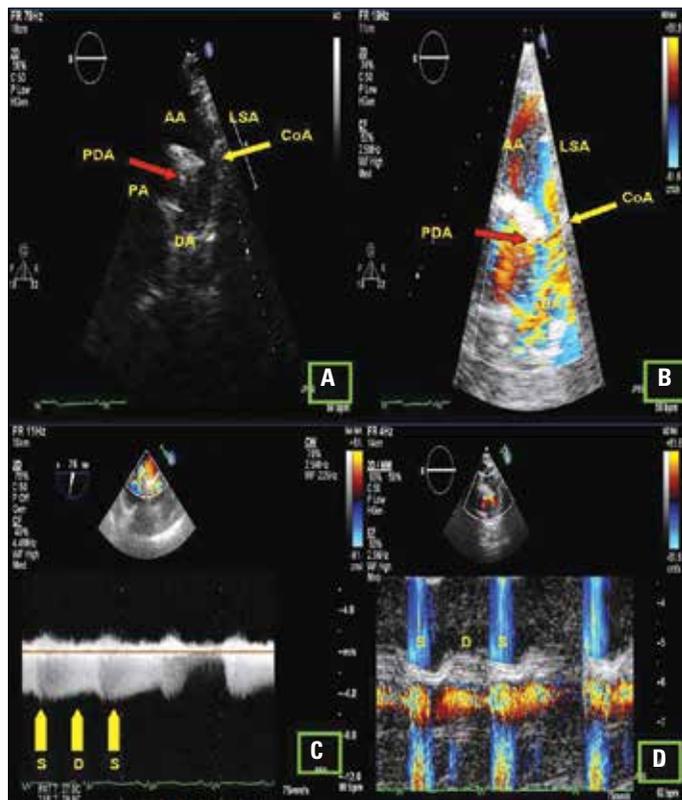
A) Suprasternal window of TTE showing a linear structure at the descending aorta (yellow arrow) and patent ductus arteriosus under that structure (red arrow). B) Suprasternal window of color Doppler TTE showing flow from descending aorta to the pulmonary artery (red arrow); C) Color Doppler with continuous Doppler TEE showing flow signals moving from pulmonary artery to descending aorta in systole and diastole (red arrow). D) Suprasternal window of color from M-mode TTE showing that the flow is between descending aorta to pulmonary artery is continuous
